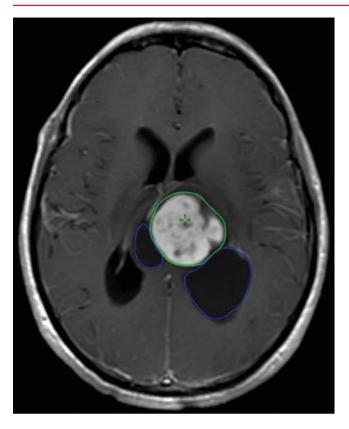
Delineation of the treatment volumes on diagnostic pre-op MRI: pre-op tumor (green) and pre-op cyst (blue)
